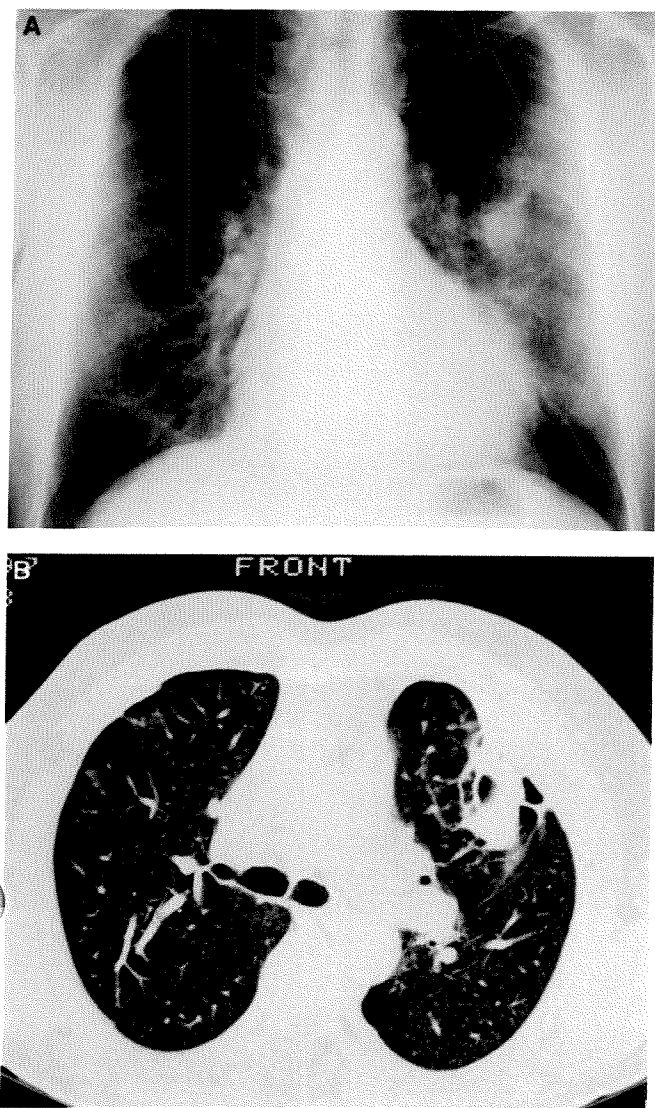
Rounded atelectasis in a 57-year-old sheet metal worker. (A) Presentation as a mass in the left chest. (B) CT scan showing pleural base and infolding of structures.
